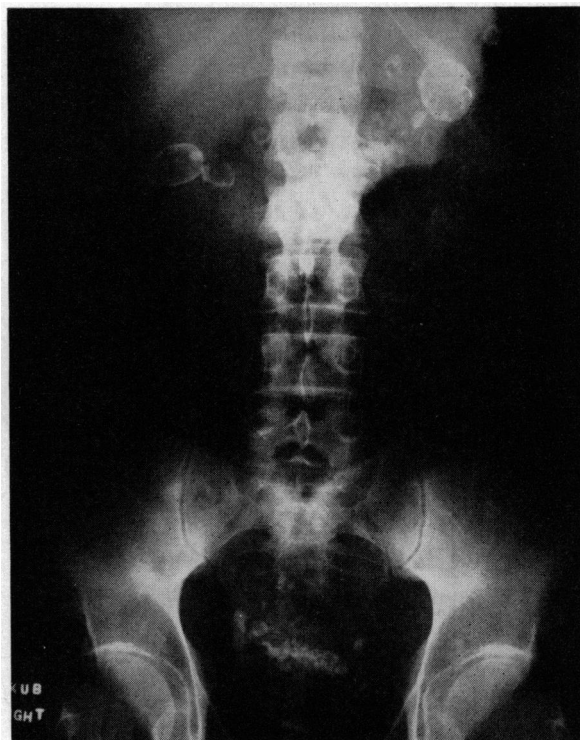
Roentgenographic appearance of calcified intraperitoneal oil granulomas.
